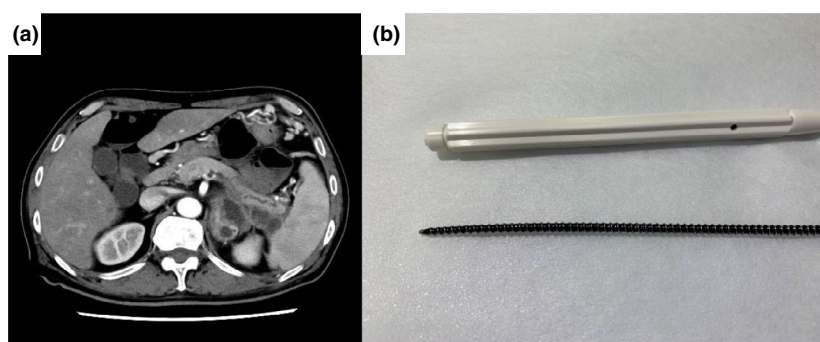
(a) Computed tomography image before the procedure revealed a pancreatic duct dilation at the tail side, obstructive pancreatitis, and peripancreatic abscess. (b) The picture shows the magnification of the tip and distal end of the newly designed drill dilator, Tornus 25. This device has spiral threads around the shaft and a rotatable handle at the distal end. A 0.025 inch guidewire is available.
